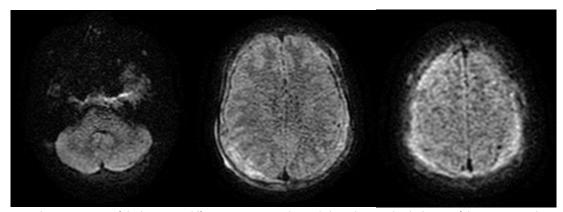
Image showing sections of the brain MRI, diffusion sequence, in the axial plane showing the thickening of the meninges in hyper-signal
